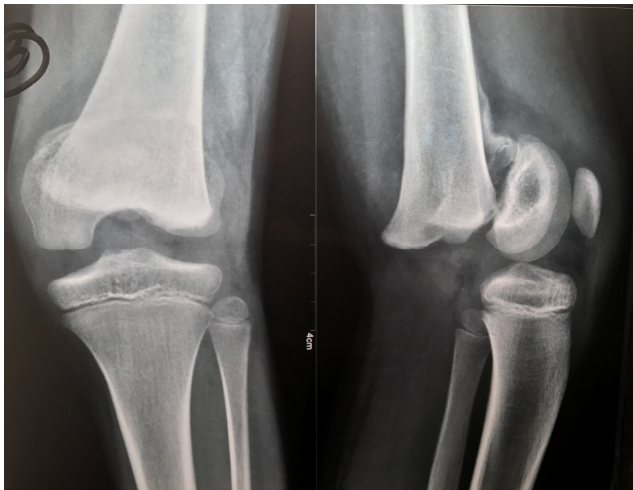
AP and lateral radiographs
